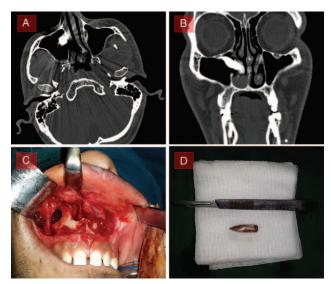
Retrieval of the foreign body that lodged in the maxillary sinus by Caldwell–Luc approach. (A) Axial view of computed tomography scan show foreign body lodged in the right maxillary sinus. (B) Coronal view of computed tomography scan. (C) Caldwell–Luc approach for bullet extraction from the maxillary sinus. (D) Bullet after its removal from the maxillary sinus.
